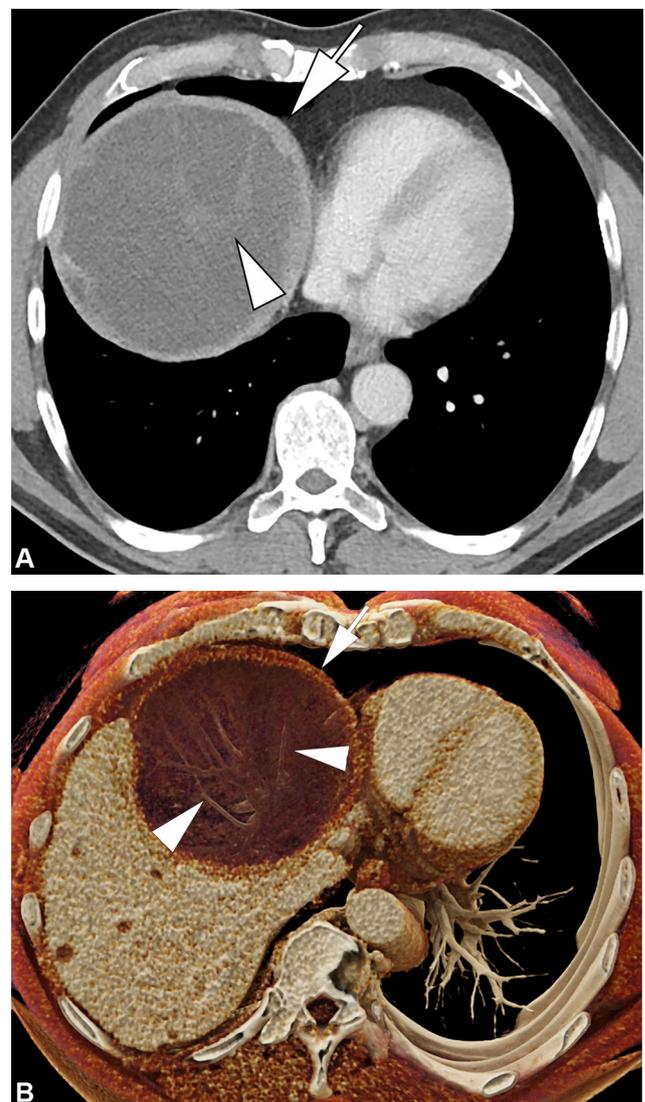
A 58-year-old man with history of metastatic gastrointestinal stromal tumor. A. Two-dimensional CT image obtained in the axial plane during the portal venous phase of enhancement shows a cystic mass (arrow) with multiple subtle internal septations (arrowhead). B. CT image obtained in the axial plane during the portal venous phase of enhancement with cinematic rendering can improve depth perception and appreciation of the subtle internal septations (arrowheads) in the complex cystic mass (arrow).
